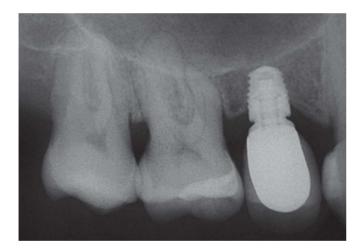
Control periapical radiograph after 18 months.
